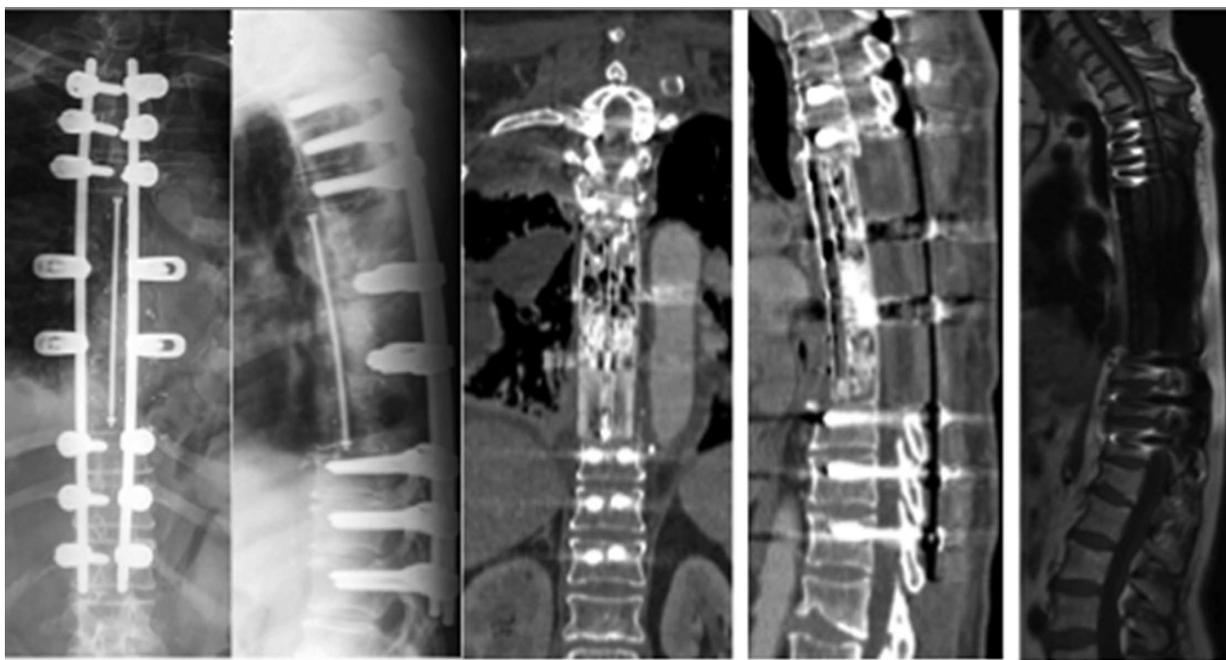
Postoperative radiographs, CT scan, and MRI showing anterior reconstruction with stacked carbon cage packed with bone graft. MRI indicates magnetic resonance images; CT, computed tomography.
